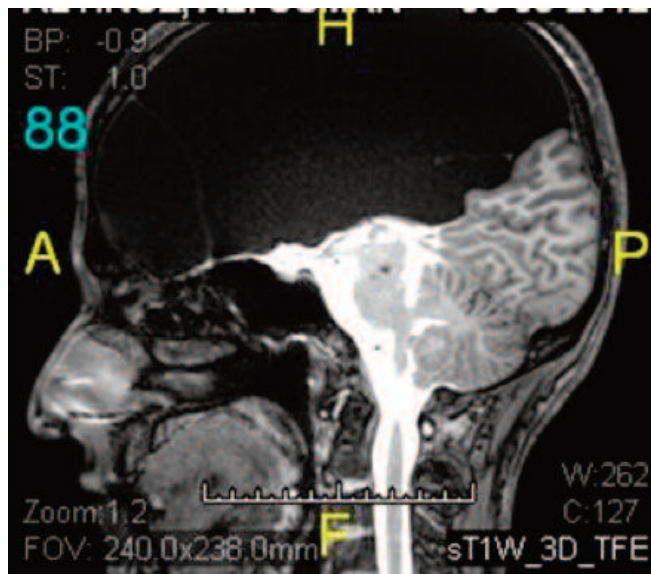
T2 weighted sagittal section of MRI of the brain revealed giant arachnoid cysts on the convexity of frontal lobe.
